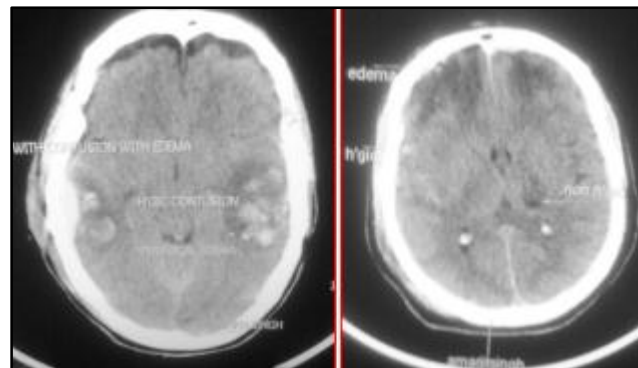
CT Axial One Images showing B/I Multiple Haemorrhagic Contusions another Image showing Non-Haemorrhagic Contusions
